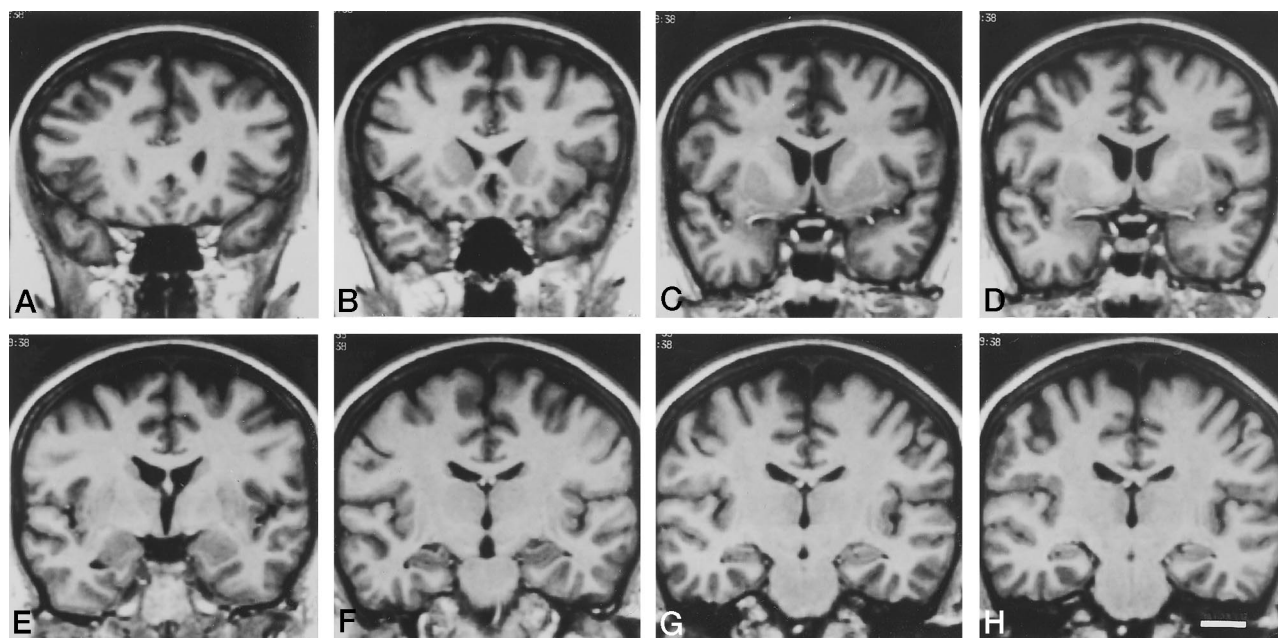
Coronal MR images in a 43-year-old woman taken from eight rostrocaudal levels, from which the higher-magnification images shown in Figure 4 were enlarged. A is the most rostral and H is the most caudal. Scale bar (in H) = 20 mm.
